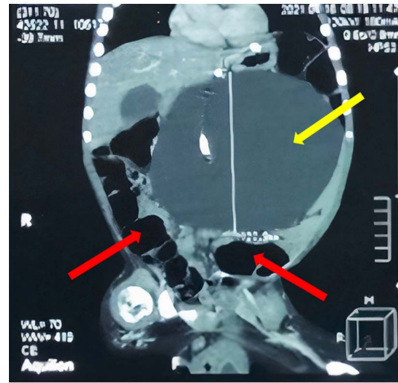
Abdominal CT, coronal section. Note the low-density circumscribed abdominal mass mainly occupying the left side of the peritoneal cavity, which is the abdominal CSF pseudocyst (yellow arrow). It mass affects bowels that are moved into the right side of the peritoneal cavity (red arrow).
